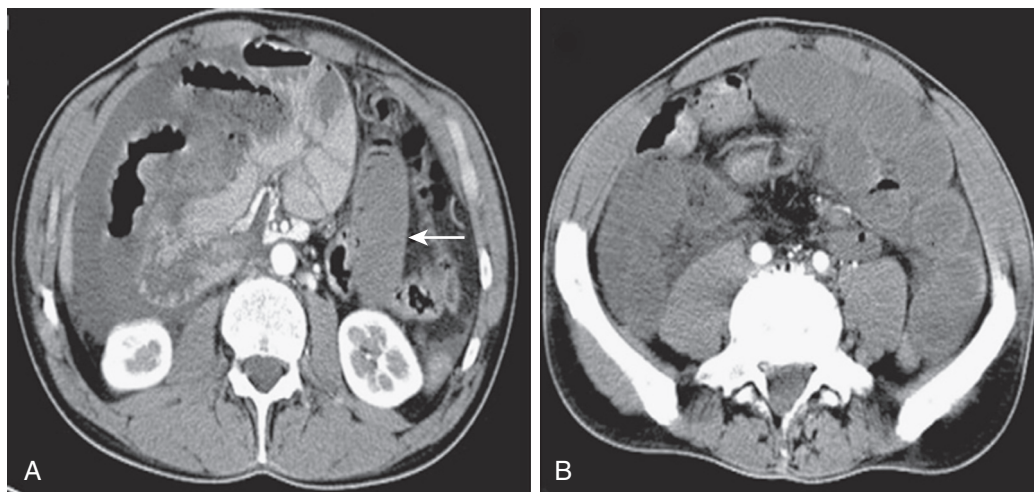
Strangulation in intestinal obstruction. A. Axial image of CT in a patient with abdominal pain, nausea, and vomiting. The arrow shows a nonperfused segment of the proximal jejunum in late arterial phase CT acquisition. Note the abnormal superior mesenteric vascular course, which suggests midgut volvulus. B. Axial at the level of the superior aspect of the pelvis shows the absence of perfusion of mesenteric SB, consistent with infarction confirmed at surgery.
